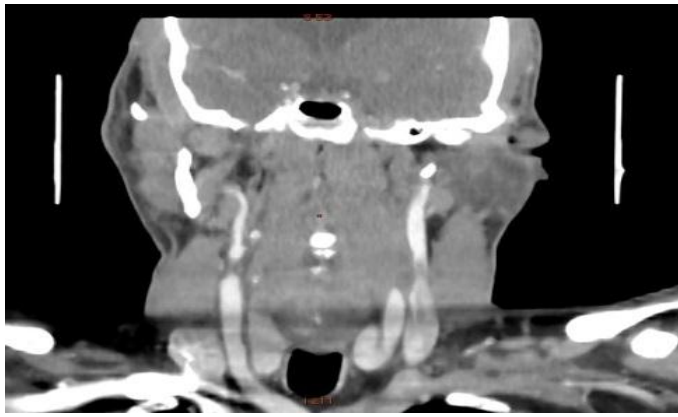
Computed tomography with contrast showing left internal carotid obstruction.
